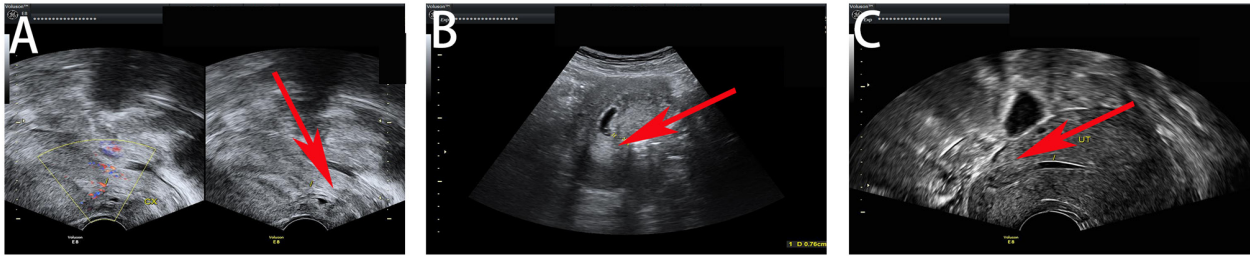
Ultrasound images of three patients' incomplete abortion (red arrow). (A) Case 2, (B) case 3 and (C) case 4.
